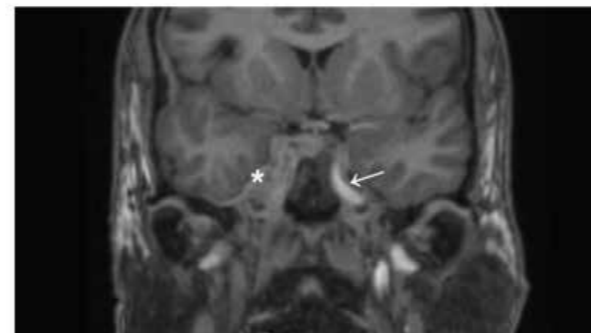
Coronal T1-weighted MRI showing extension of the right orbital mass (asterisk) to the cavernous sinus with non-filling right ICA in comparison to normal left ICA (arrow).
